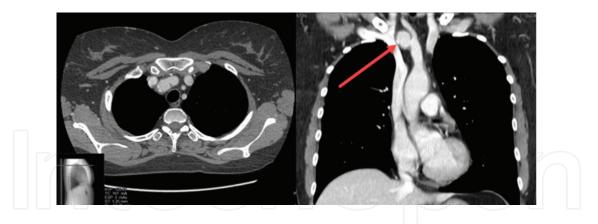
CT scan of a 22-year-old BD patient presenting with a right subclavian artery aneurysm.
